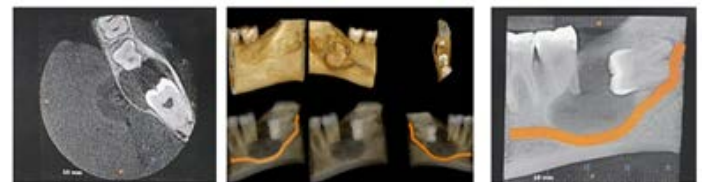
CBCT shows the cyst lining
